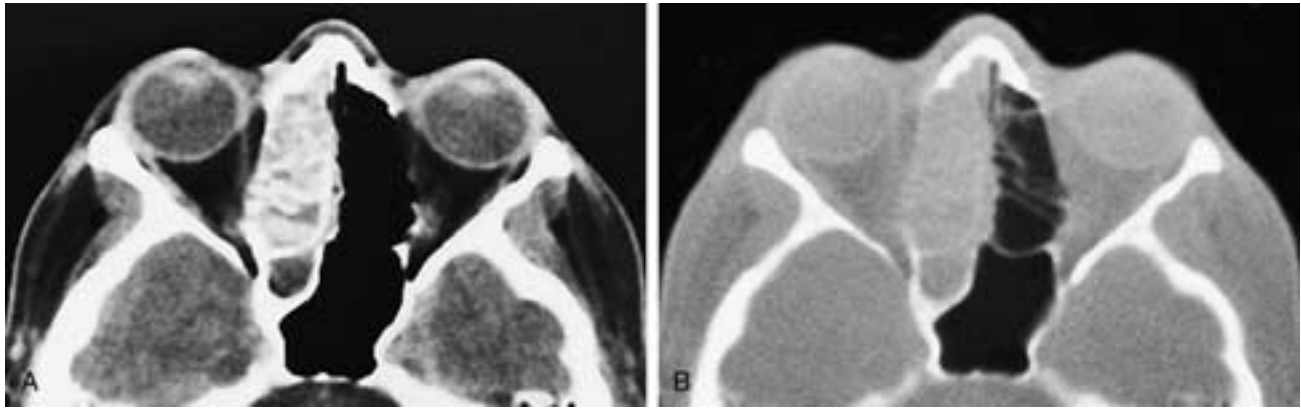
Axial CT scans at narrow (A) and wide (B) window settings show inflammatory disease in the right ethmoid and sphenoid sinuses. In (A), there appears to have been a left sphenothmoidectomy, as the septations are not seen. However, in (B), the left ethmoid septa and the anterior sphenoid sinus wall are intact, indicating that no surgery was performed. In order to avoid such mistakes, these cases should always be viewed at wide window settings.
